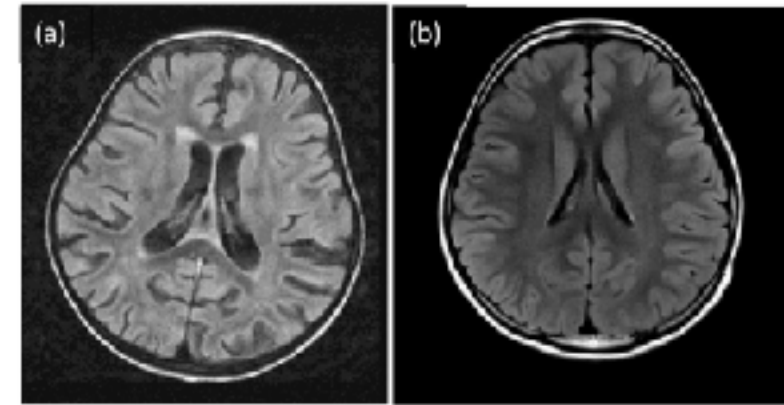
A 34-month-old ESRD girl caused by bilateral renal hypodysplasia. Her initial MRI FLAIR T2 imaging of brain showed moderate ventricular dilatation and diffuse cortical atrophy (a). She received a deceased-donor kidney transplant at the age of 6 years. The follow-up MRI imaging of brain showed decreased ventricular size and significant improvement of cortical atrophy (b).
